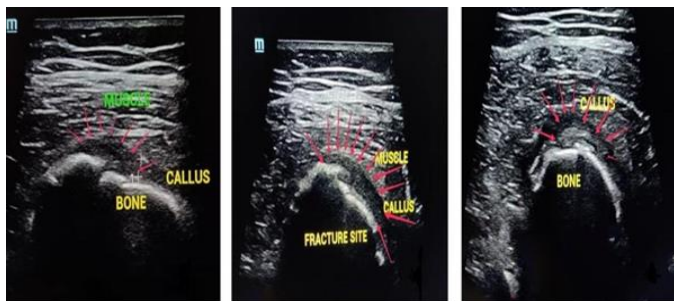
Ultrasonography showing callus formation at fracture site after PEMF therapy: a. 3 months post-PEMF; b. 6 months post-PEMF; c. 2 years post-PEMF.
